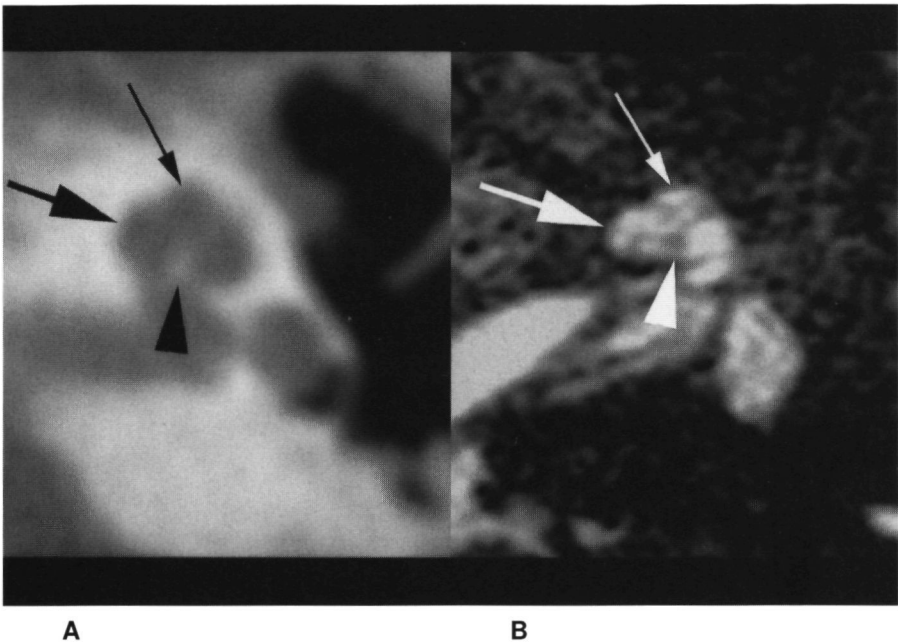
Axial CT image (A) and three-dimensional Fourier transformation-constructive interference in steady state MRI image (B) at the level of the second and apical turn of the left cochlea obtained from patient III-3 showing separation between second and apical turns, invisible on CT scan and partially visible on MRI scan, as well as hypoplasia of the modiolus. The second turn (large arrow) and apical turn (small arrow) of the cochlea cannot be distinguished on CT scan. They are separated by an incomplete hypointense structure, however, representing the bony septum between the two turns of the cochlea (the bony spiral lamina and basilar membrane) on MRI. The modiolus is hypoplastic (arrowhead).
